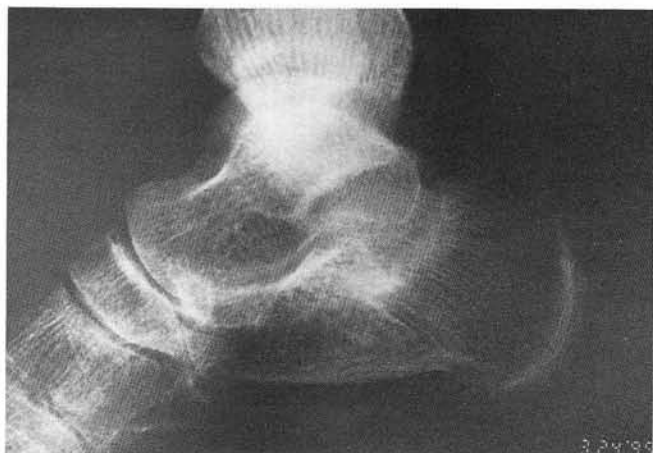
Lateral radiograph showing mild collapse despite immobilization and partial unweighting of foot.
